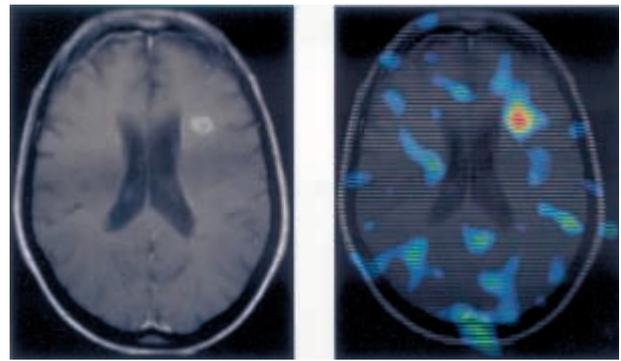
Pathological uptake of [<sup>11</sup>C]PK11195 in a focal white matter lesion observed on the corresponding T1-weighted Gd MR scan in a patient with active relapsing-remitting MS.
